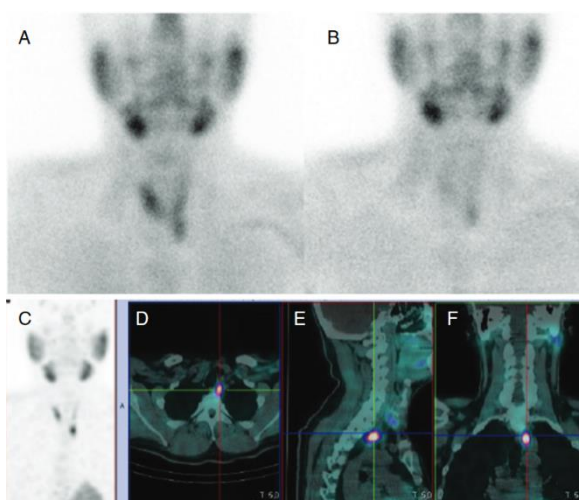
COMBINATION OF 99mTc-MIBI AND SPECT/CT. ADAPTED FROM (30).
